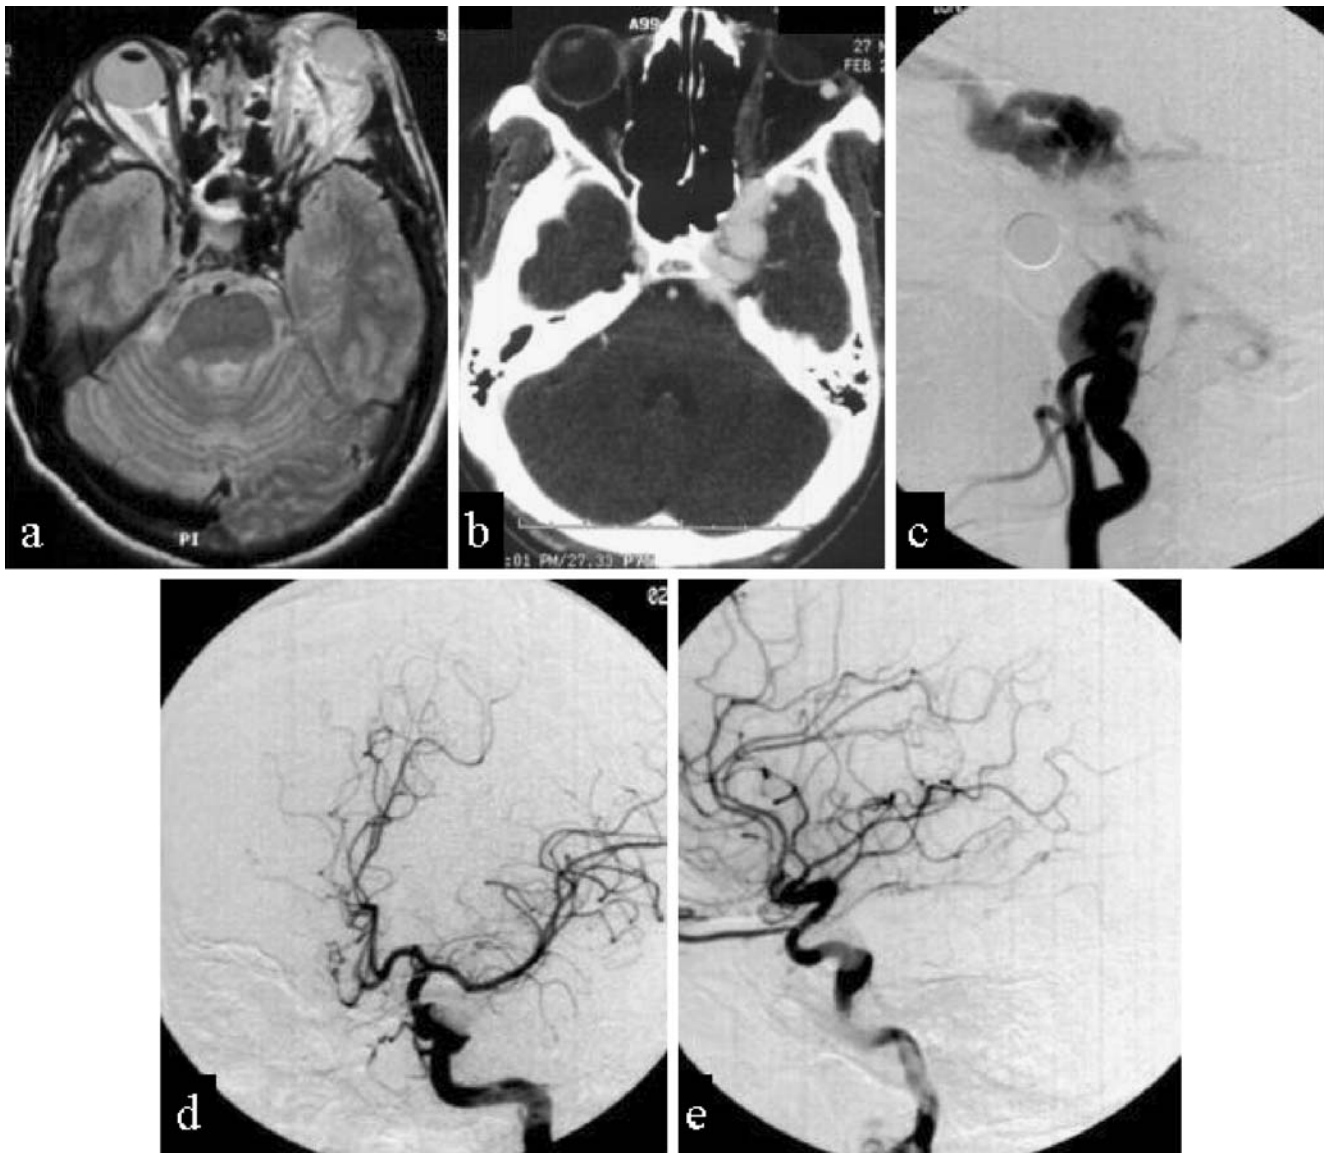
a, b Axial MRI and CT scan shows enlarged left cavernous sinus with left sided proptosis. c Injection of the left ICA shows the CCF. Note drainage into the inferior petrosal sinus and mild cortical reflux. d, e Angiogram after embolization shows complete closure of the fistula
